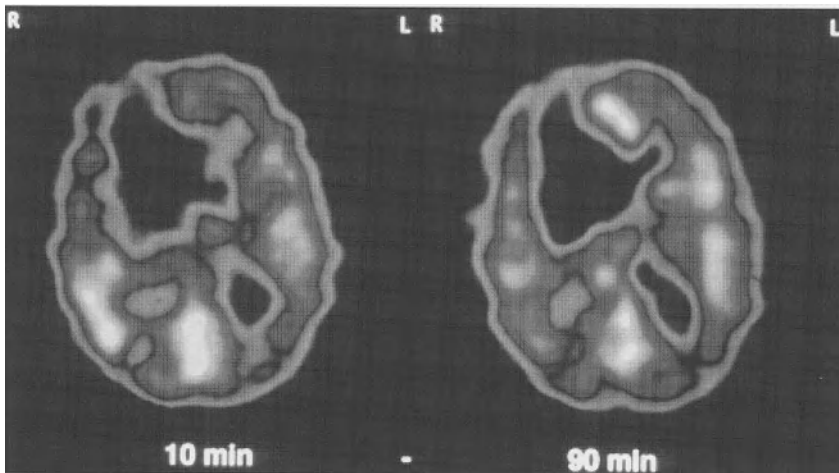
Single photon emission computed tomographic scans with radiolabelled MK801 of a patient with subdural haematoma showing glutamate receptor activation
